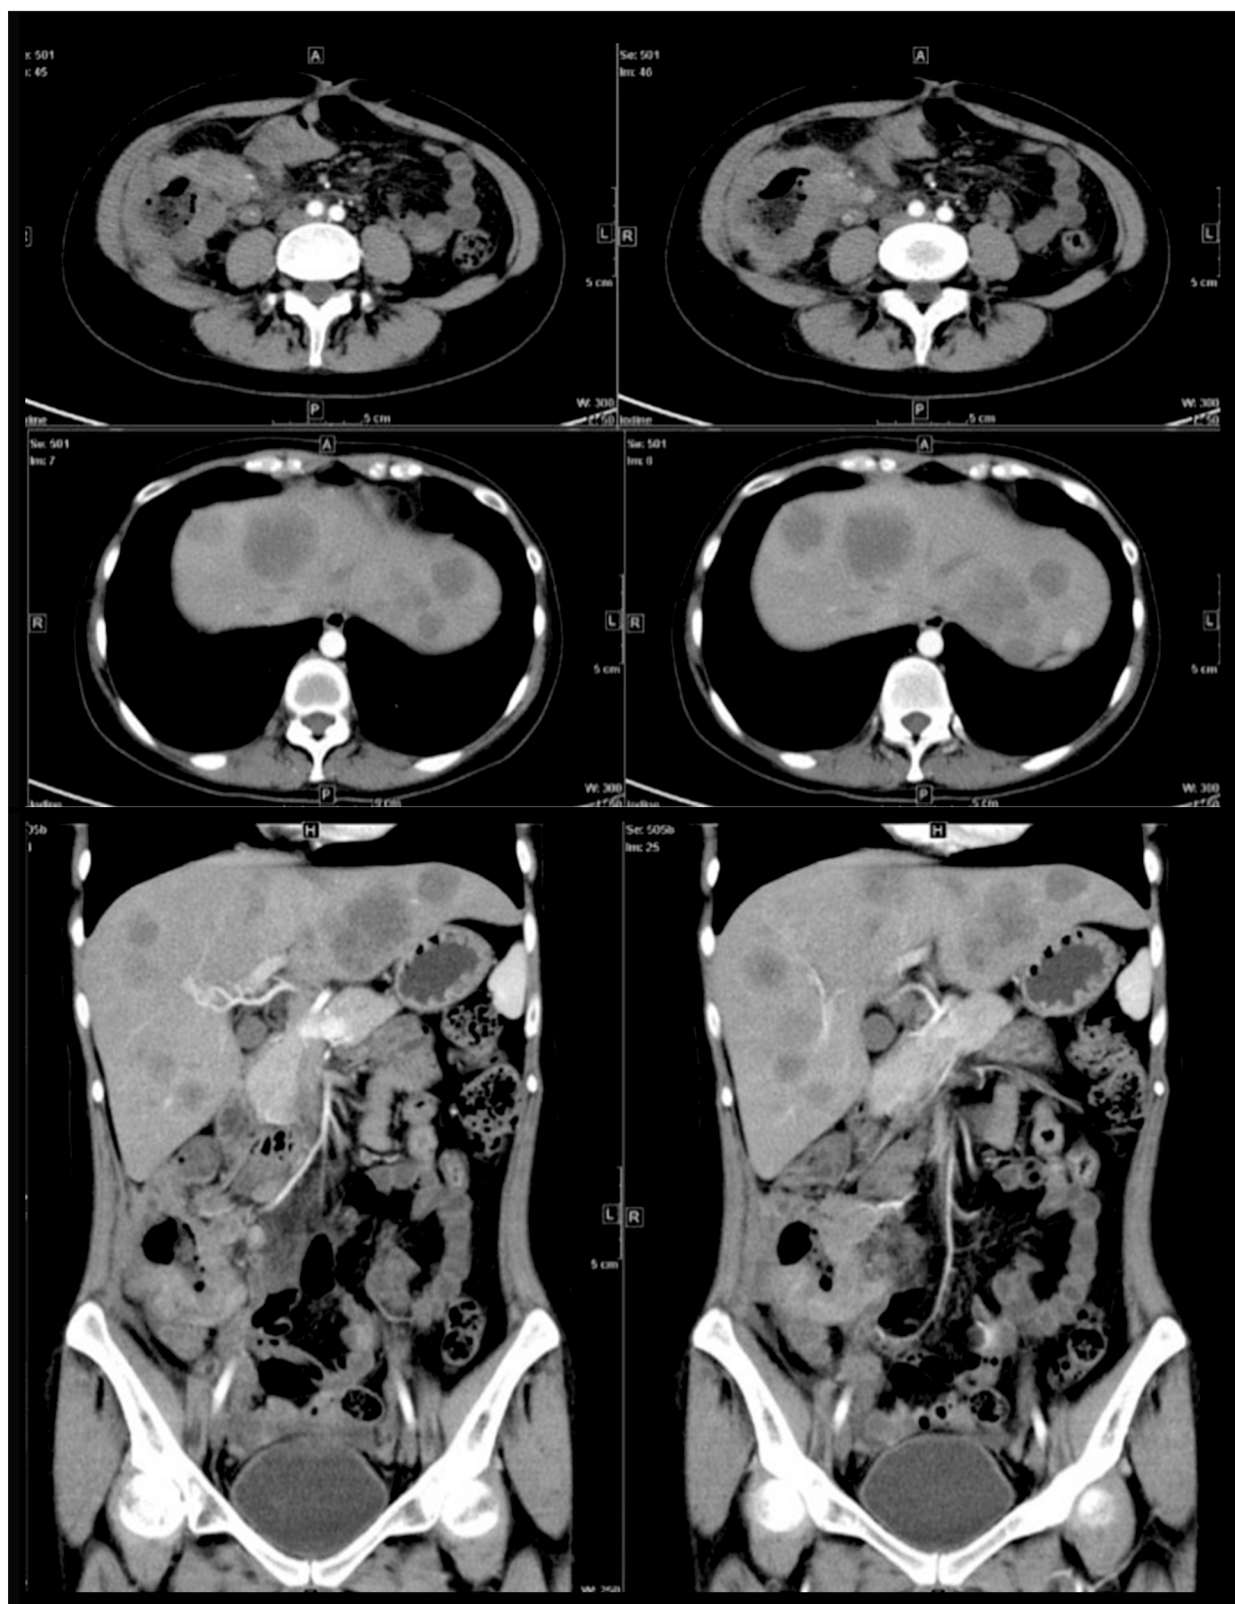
Contrast-enhanced computed tomography showed a large mass in the ascending colon of this patient, along with multiple liver metastases.
